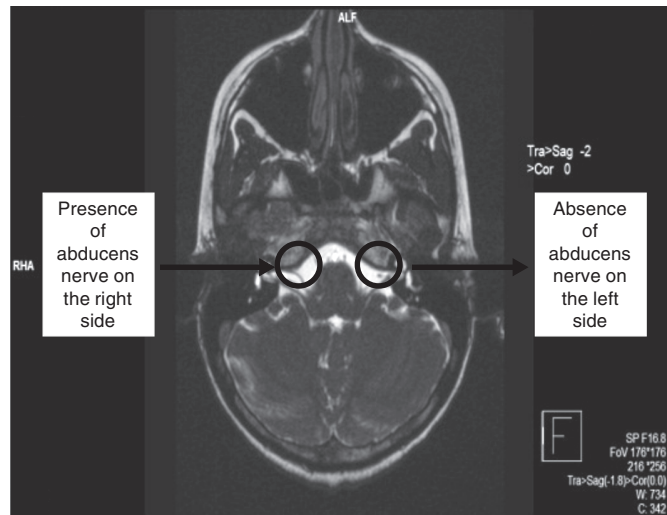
MRI scan showing absence of abducens nerve on the left side
